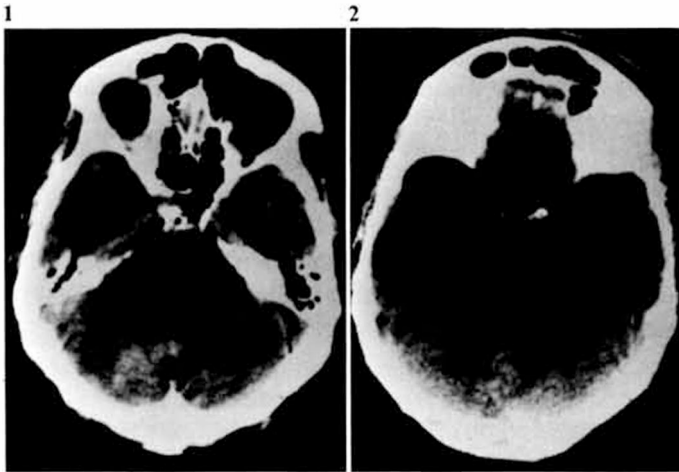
CT of the posterior fossa demonstrating a high-density lesion in the posterior aspect of the right cerebellar hemisphere.
